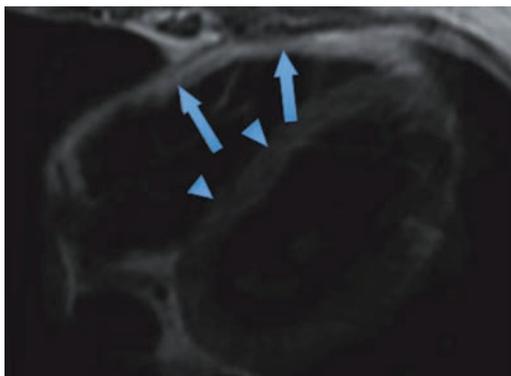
Black blood T1-weighted cardiac MR image showing diffuse fatty infiltration and thinning of right ventricle wall. Increased signal intensity in free wall (arrows) impaired with the intermediate signal intensity of the septum (arrowheads) is a sign of fatty infiltration (from our own archives).
